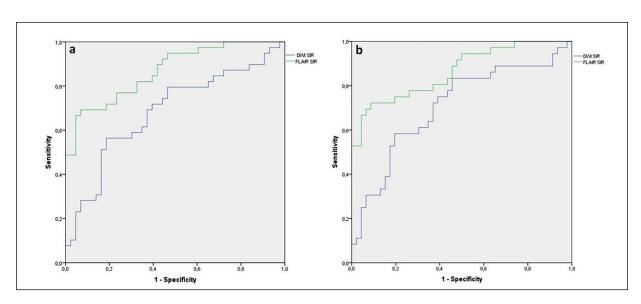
Receiver operating characteristic curve analysis for the first 4.5 (a) and 6 (b) hours from symptom onset till MRI.
